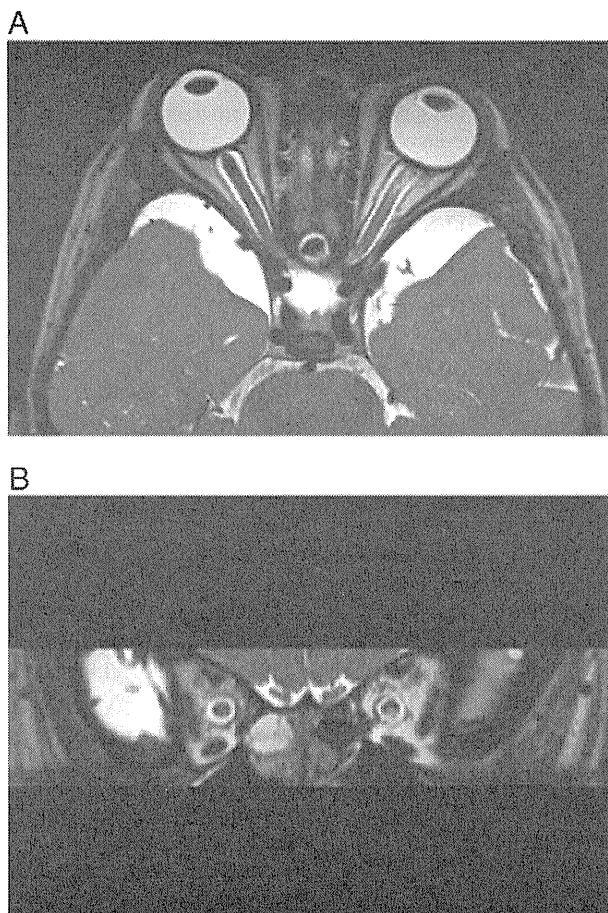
a and b. (Case 5) MRI: T2-weighted axial and coronal MRI with single-slab 3D-TSE acquisition. Patchy increased signal intensity in the left optic nerve and dilated CSF spaces along the bilateral perineural sheaths. Note bilateral arachnoid cysts in the middle cranial fossa.
